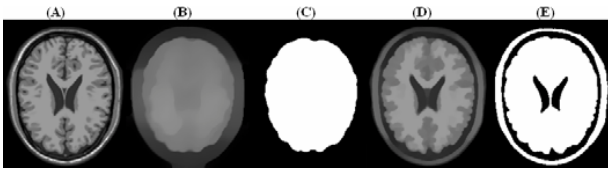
TV+ $L^1$  model for brain and ventricle extraction. (A) Input brain MR image,  $f$ ; (B)  $u$  with  $\lambda = 0.2$ ; (C) Thresholding on (B) to get brain region; (D)  $u$  with  $\lambda = 0.6$ ; (E) Thresholding on (D) to get ventricle regions.
